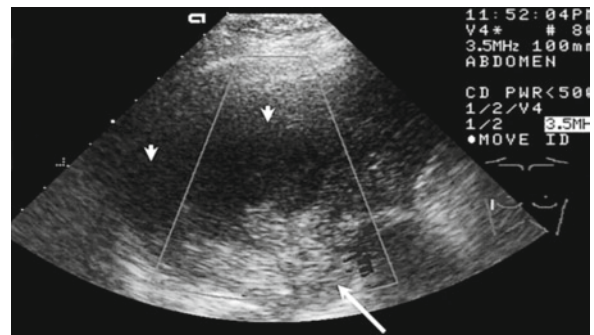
(a) Central tumor in the left upper lobe (*broken line*); behind it there is atelectatic lung tissue with a regular vascular architecture. (b) Computed tomography image of the tumor and the atelectasis in the upper lobe. (c) Large tumor (*arrow*) in the right lower lobe; in the marginal area there is atelectatic lung tissue surrounded by a pleural effusion. Sonographic biopsy of the tumor indicated small-cell carcinoma
